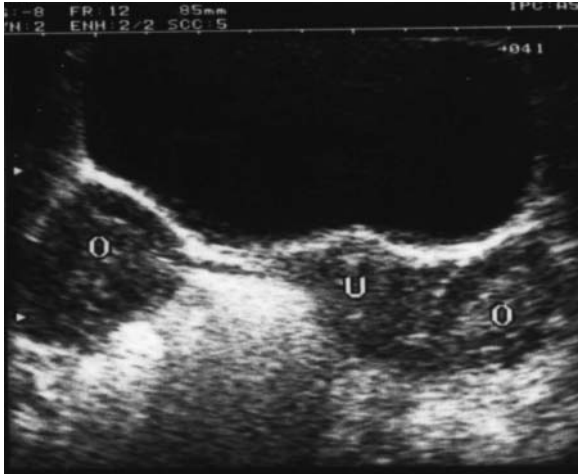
Sonogram by abdominal route depicting the polycystic appearance of the ovaries in an adolescent girl with PCOS. Note that both ovarian sections are greater than the uterine section. In this representative case, the increased number of subcapsular follicles and the stromal hyperplasia are easily seen.
